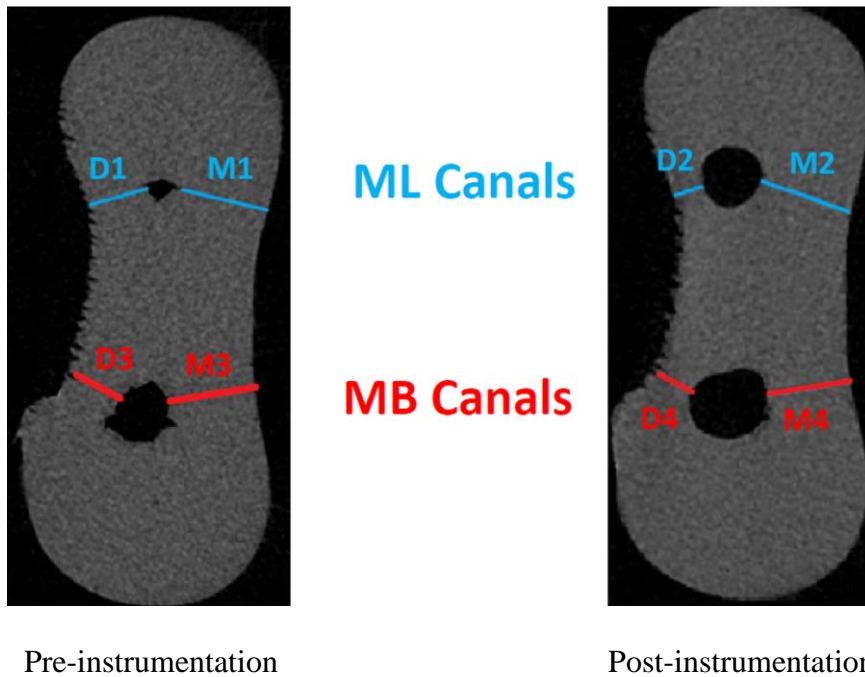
Cone-beam computed tomography images at the coronal level from before and after instrumentation with the corresponding measurements for canal transportation and centering ratios
